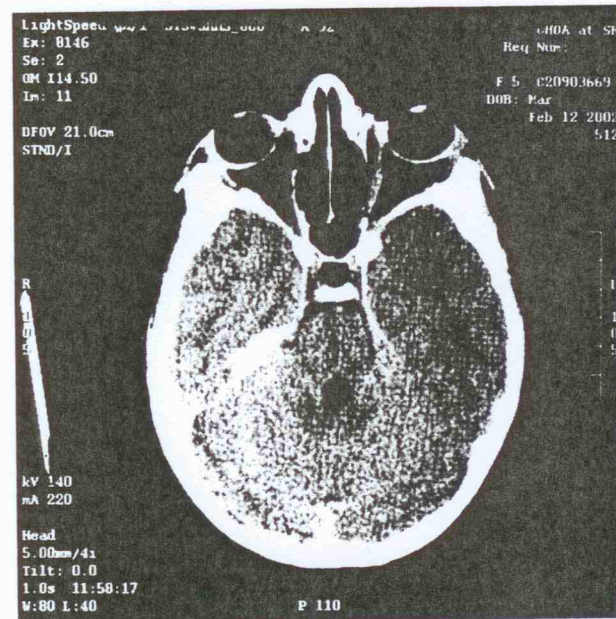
CT scan of orbits show marked proptosis OU.
